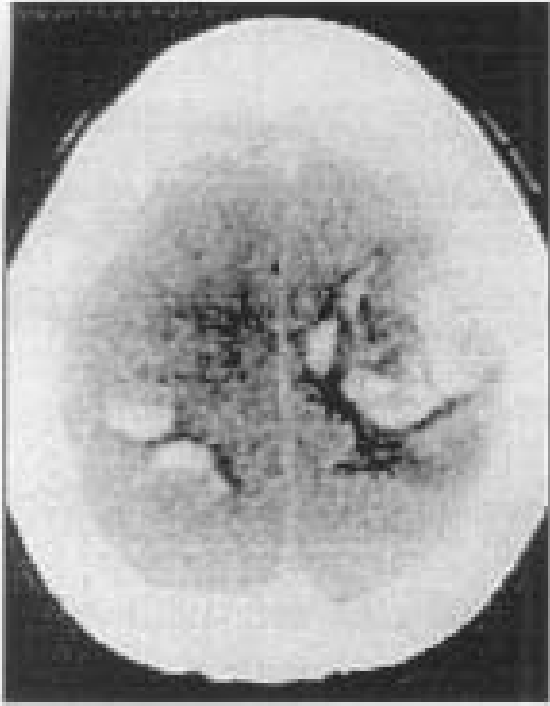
Noncontrast axial head CT scan shows bilateral multifocal hemorrhages.
